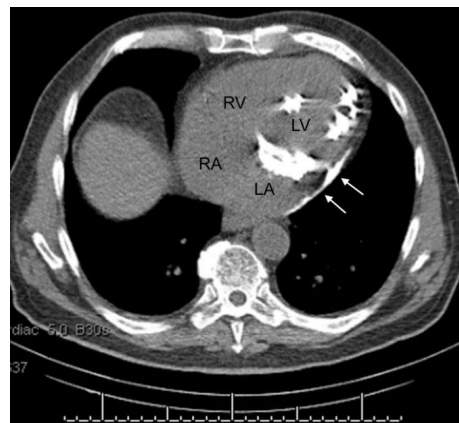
The axial image of low-dose CT during MPI demonstrated a significant amount of calcification at mitral valvular annulus, LV myocardium at septum, and free wall as well as pericardium (white arrows). [LA = left atrium; LV = left ventricle; RA = right atrium; LV = left ventricle.]
